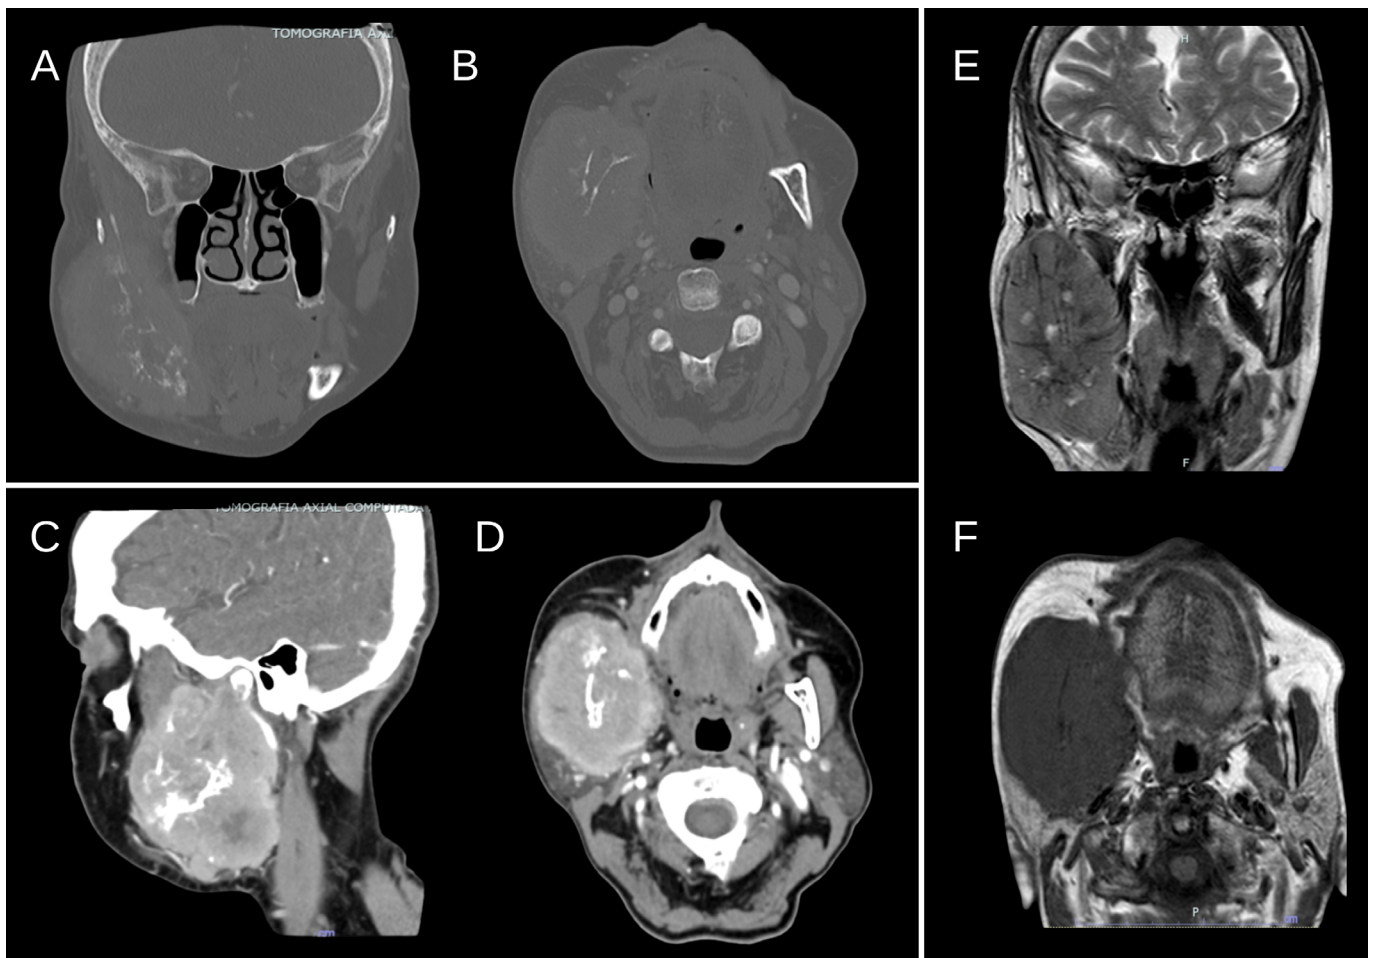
Radiological features. A-D. Contrast-enhanced CT scan of the head and neck (A-B: T1-weighted, C-D: T2-weighted). E-F. MRI of the head and neck. E: T2-weighted, F: T1-weighted. Higher signal uptake on T2-weighted is a characteristic radiological finding in osteolytic metastatic bone tumors.
